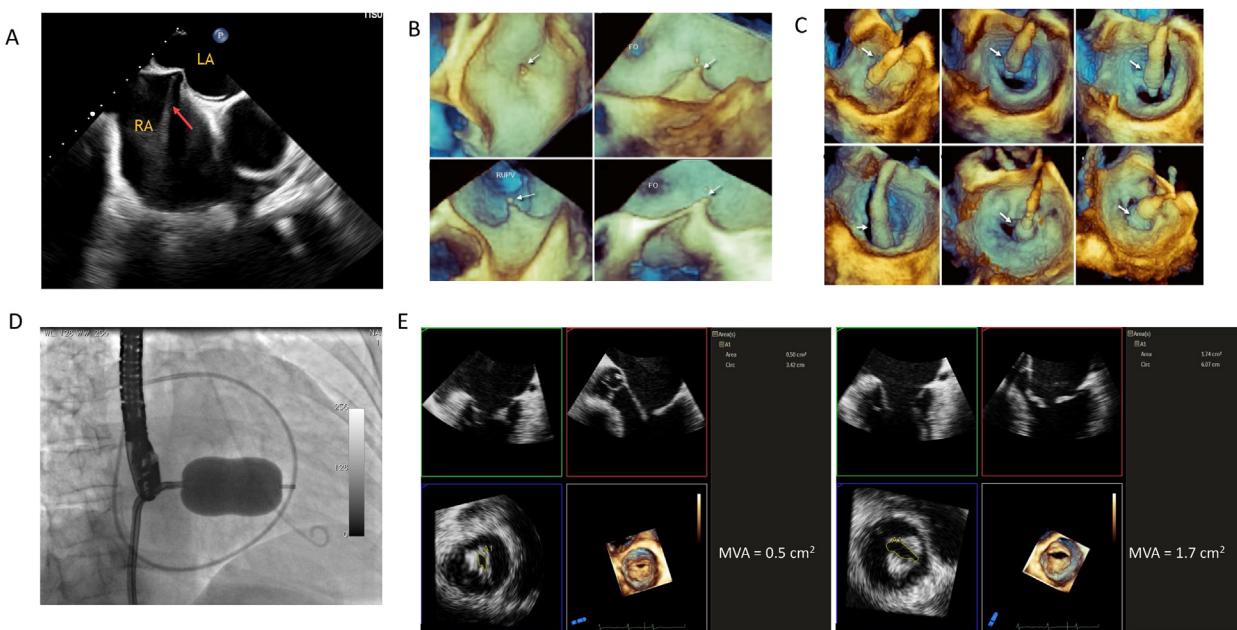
TEE guidance of PBMV. (A) TEE showing the short-axis view marking the transseptal puncture needle (red arrow) in position and the atrial septum bowed into the left atrium. (B) Left atrial view during 3D TEE guidance showing the transseptal needle crossing the interatrial septum. (C) 3D TEE guidance from the left atrial view during transport of the balloon catheter (arrow) through the stenotic valve and during balloon inflation. (D) Fluoroscopic visualization of the inflated valvuloplasty balloon. (E) Pre- and immediate post-PBMV imaging (left and right, respectively) by 3D TEE to assess the MVA by planimetry from the 3D dataset. (Panels B and C: Reprinted/adapted by permission from Springer Nature, Real-Time 3D Interventional Echocardiography by Francesco Fulvio Faletra, Gila Perk, Natesa G. Pandian, Hans-Joachim Nesser, Itzhak Kronzon, © 2014, <https://doi.org/10.1007/978-1-4471-4745-9>)
